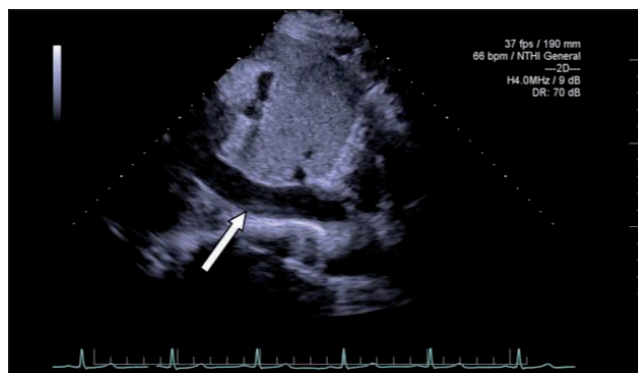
Echocardiography – thrombus formation located in inferior vena cava.
